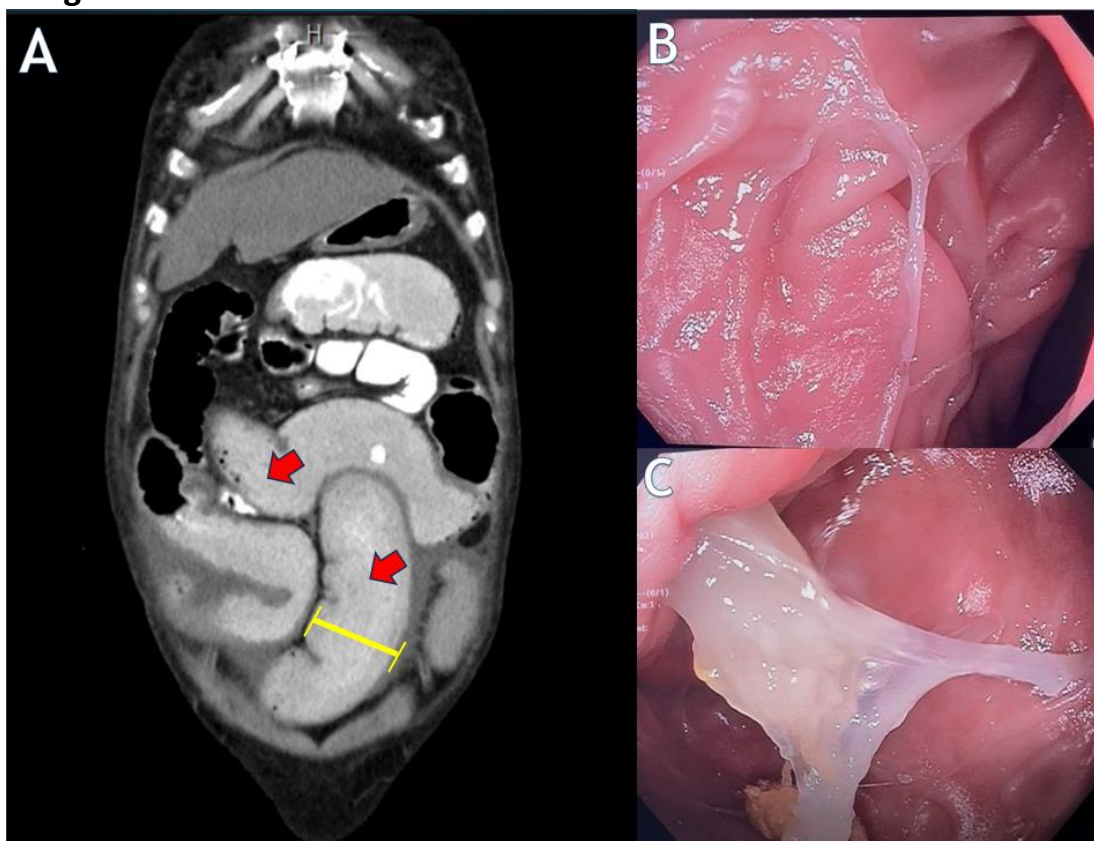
(A) Abdominal CT scan showing dilated loops of bowel (yellow line) and extensive debris in the lower portion of small intestinal (red arrows). (B) Matted, mucoid-adherent folds in the large intestine. (C) A mucus plug extending from the valve between the small and large intestine to the walls of the large intestine.
